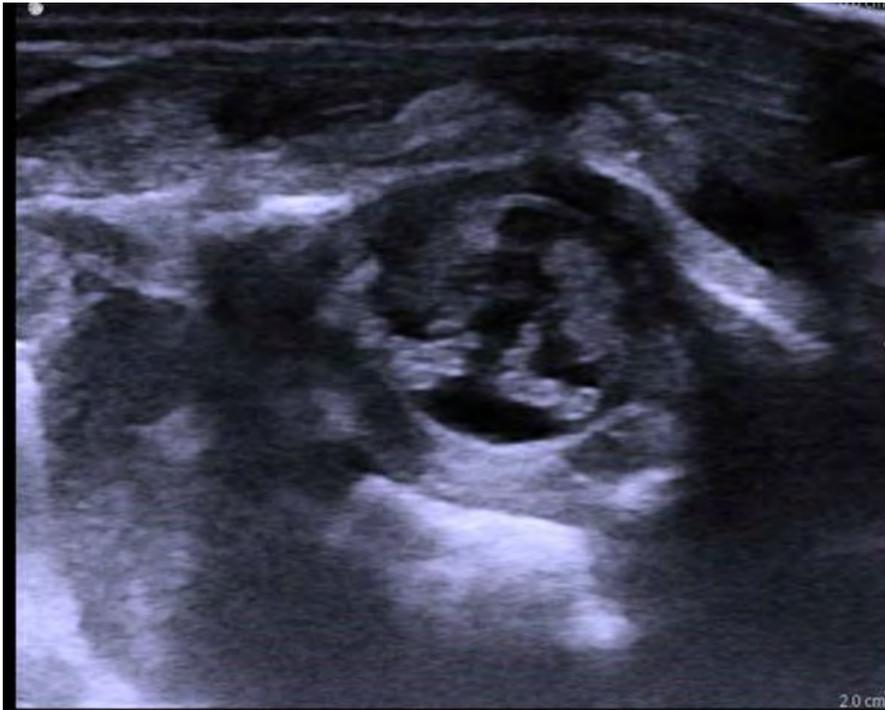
Transverse lumbar sonogram.
